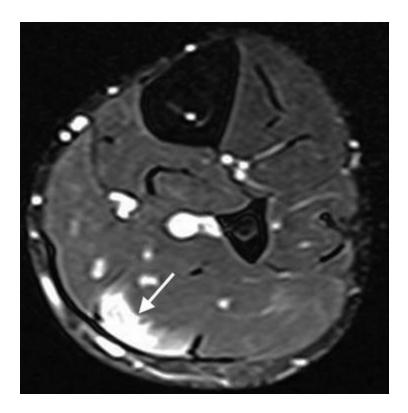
A 23-year-old man with acute left calf pain that started during a soccer match. Axial fat-suppressed T2-weighted MRI shows grade 2 injury soleus muscle and grade 1 injury of the lateral gastrocnemius muscle (arrow)
